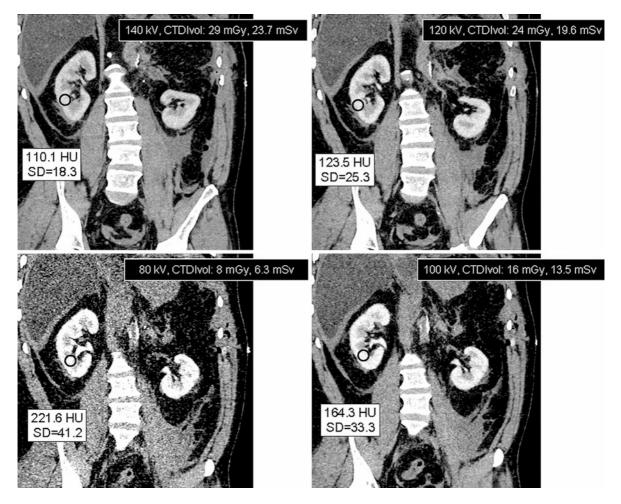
Coronal abdominal CT images acquired at different kV settings (140, 120, 100 and 80 kV) in post mortem settings shows increased image noise in hepatic parenchyma and psoas
